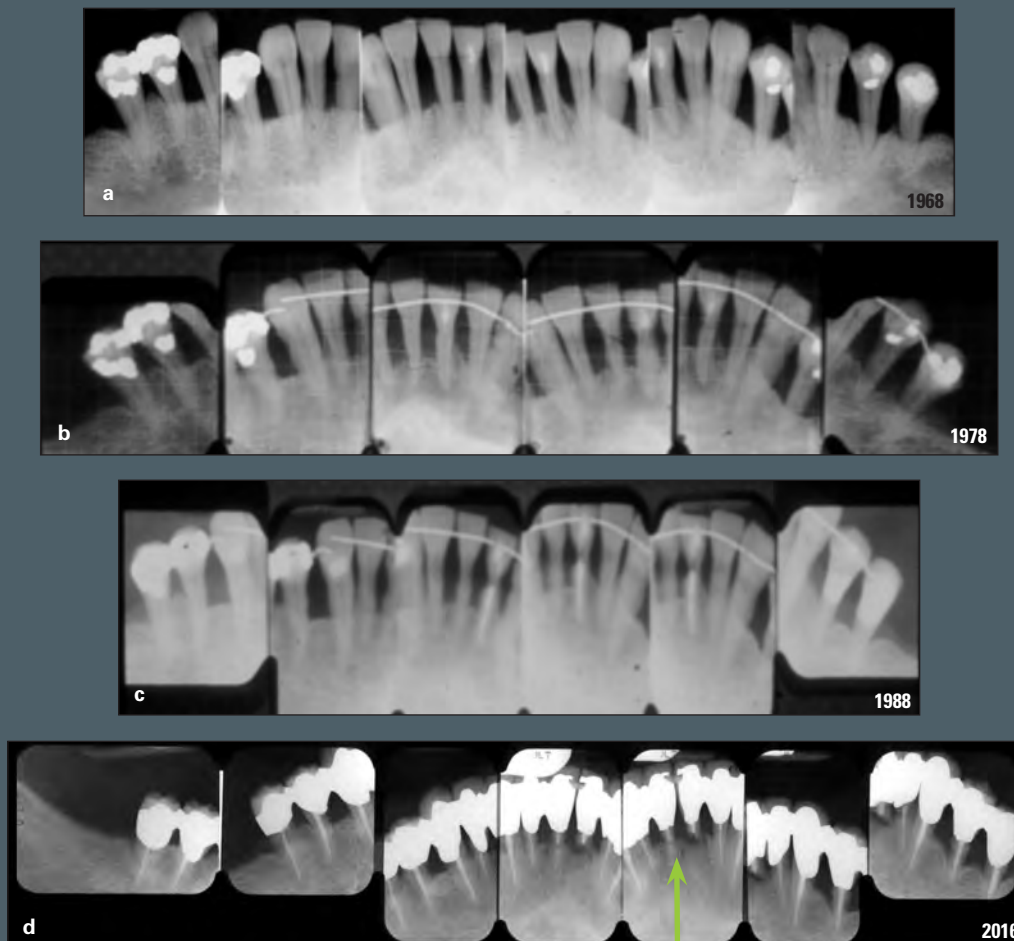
(a) This patient presented with significant loss of the periodontium in 1968. Her chief complaint was that the teeth were too mobile to masticate food. The initial therapy included nonsurgical treatment and splinting of the teeth. After this was successful, bone was harvested from the edentulous maxilla to regain periodontium where possible. (b) The patient retained all 10 teeth for 10 years. (c) Radiographs at 20 years. Her restorative dentist restored all of the teeth with fixed crowns in 1997. (d) The 2016 radiographic survey demonstrates 9 of the 10 teeth still functioning. The original endodontic treatment for the left central incisor was questionable and became problematic (green arrow).
